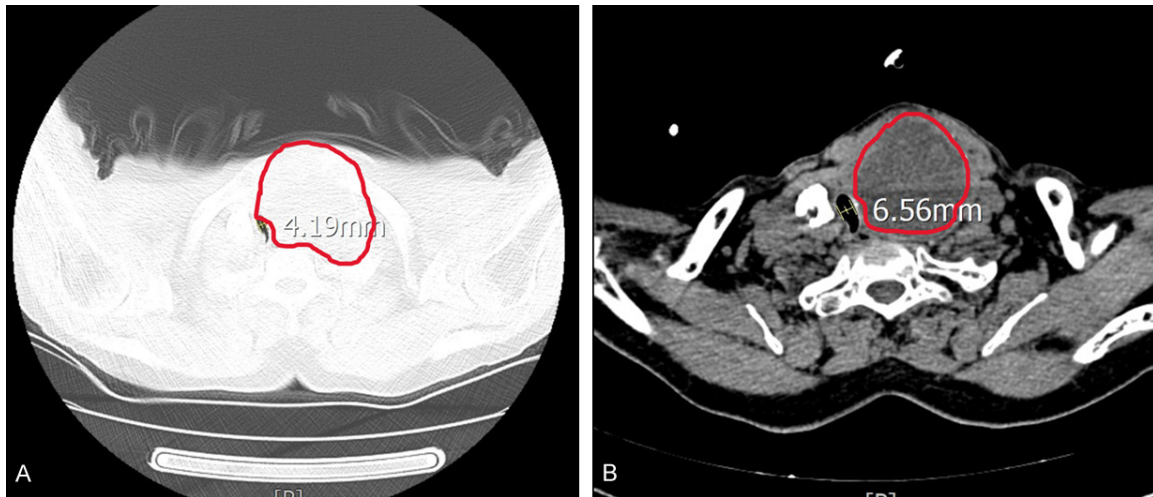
A, B. Computed tomography face images of the patient. The patient's trachea was markedly compressed, and the narrowest part of the trachea had an inner diameter of approximately 5-7 mm.
